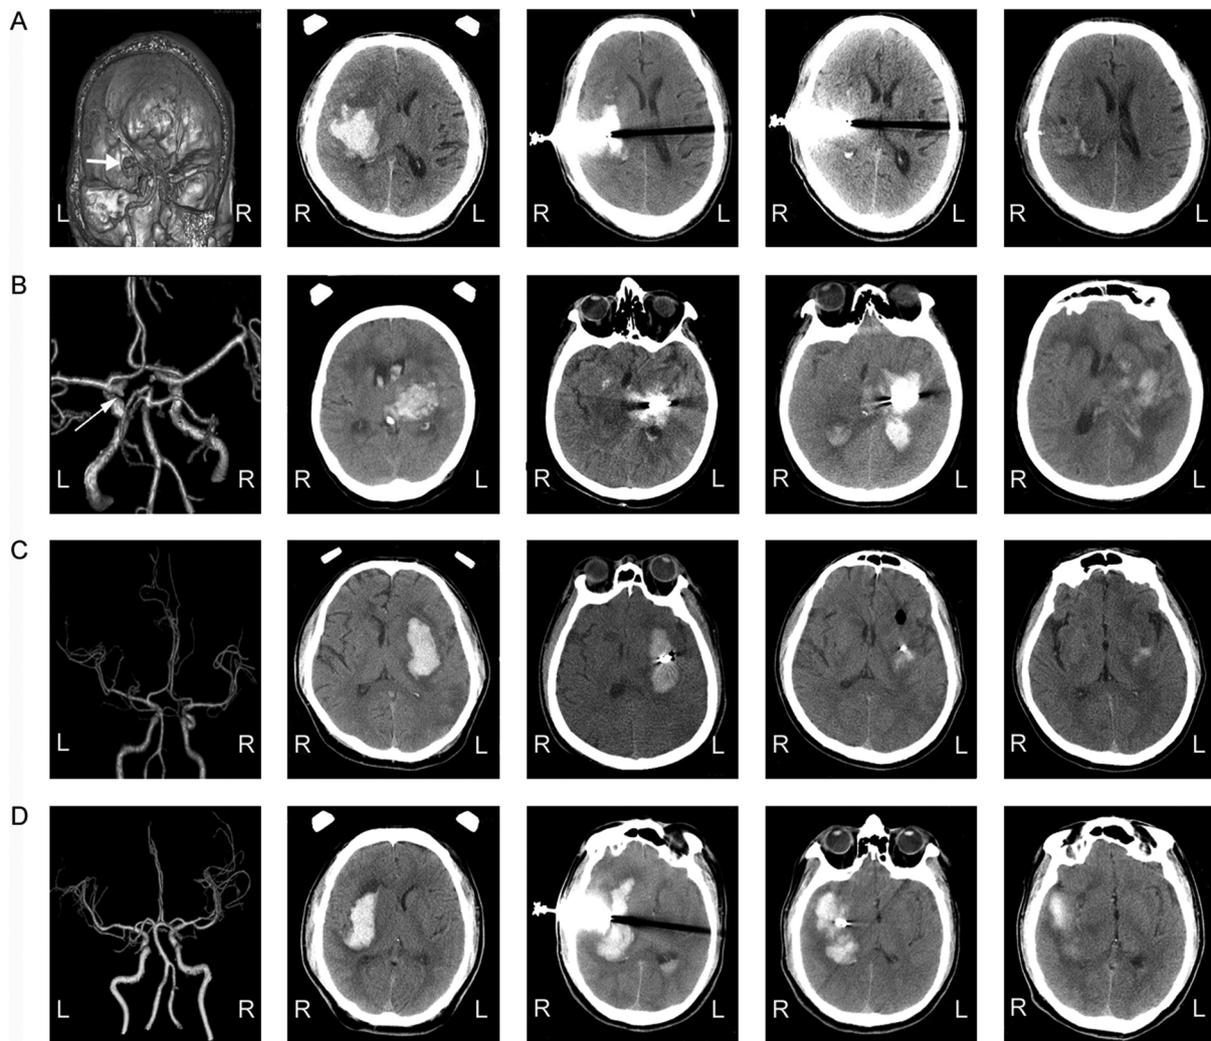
CT angiography (CTA) of intracerebral hemorrhage(ICH) patients before the surgery (left) and CT non-contrast scans after the fixation of leksell coordinate frame(middle left) on the head, after catheter placement (before thrombolysis, middle), after the first recombinant tissue plasminogen activator(rtPA) infusion and drainage (after thrombolysis, middle right) as well as after the removal of the catheter (right). (A) represents a patient harboring a hematoma on the right basal ganglia with an unruptured intracranial aneurysm(UIA) (white arrow) on the trifurcation of the left middle cerebral artery but without postoperative rebleeding ; (B) displays a patient who suffered from a supratentorial hemorrhage on the left as well as the postoperative rebleeding with an UIA (white arrow) at the C7 segment of the ipsilateral internal carotid artery; (C) shows an ICH patient with normal image findings of CTA but without postoperative rebleeding; and (D) presents an ICH patient with both normal image findings of CTA and postoperative rehemorrhage.R means right; L, left.
